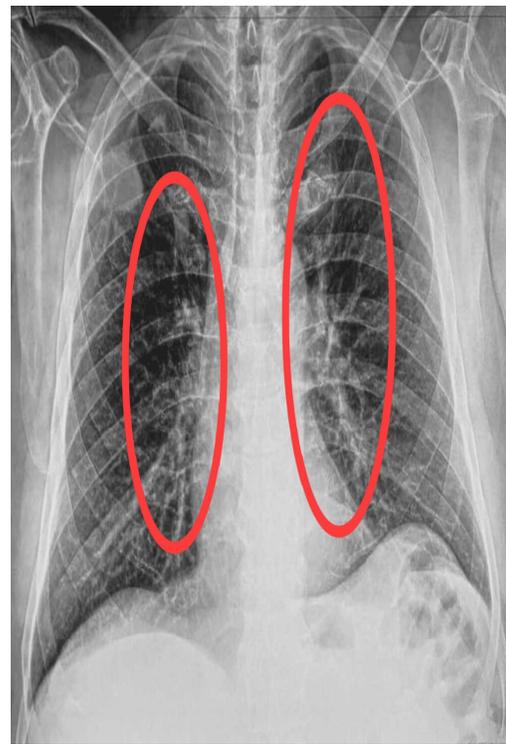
X-Ray Chest: Prominent Hilar Markings
